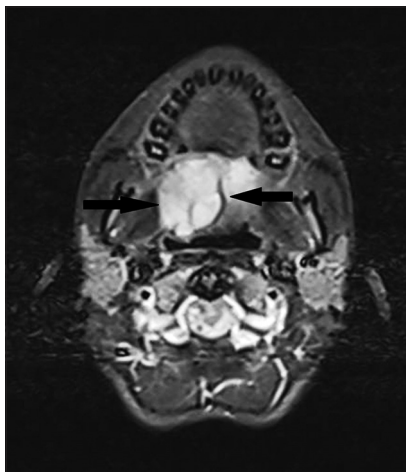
Magnetic resonance imaging axial section showing soft tissue mass (marked by arrow) arising from soft palate reaching up to the posterior pharyngeal wall causing obliteration of nasopharyngeal and oropharyngeal airway
